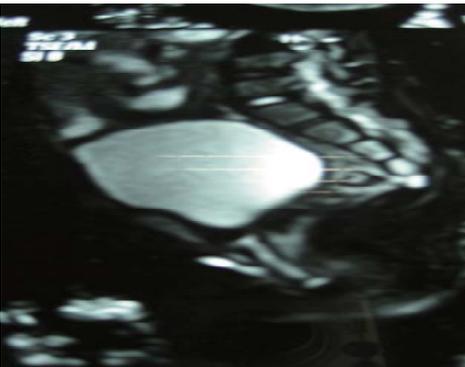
MRI pelvis shows absent image of the uterus.
